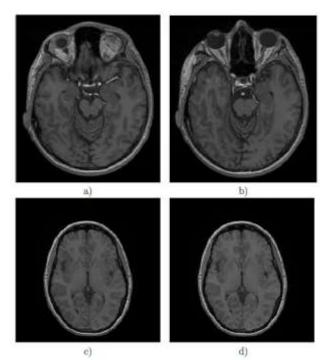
Examples of MRI 3D T1 Ax FSPGR sequence scan for the two subjects. The 54th slice for subject #4: a) pre-screaming state, b) screaming state and the 60th slice for subject #3: c) pre-screaming state, d) screaming state.
